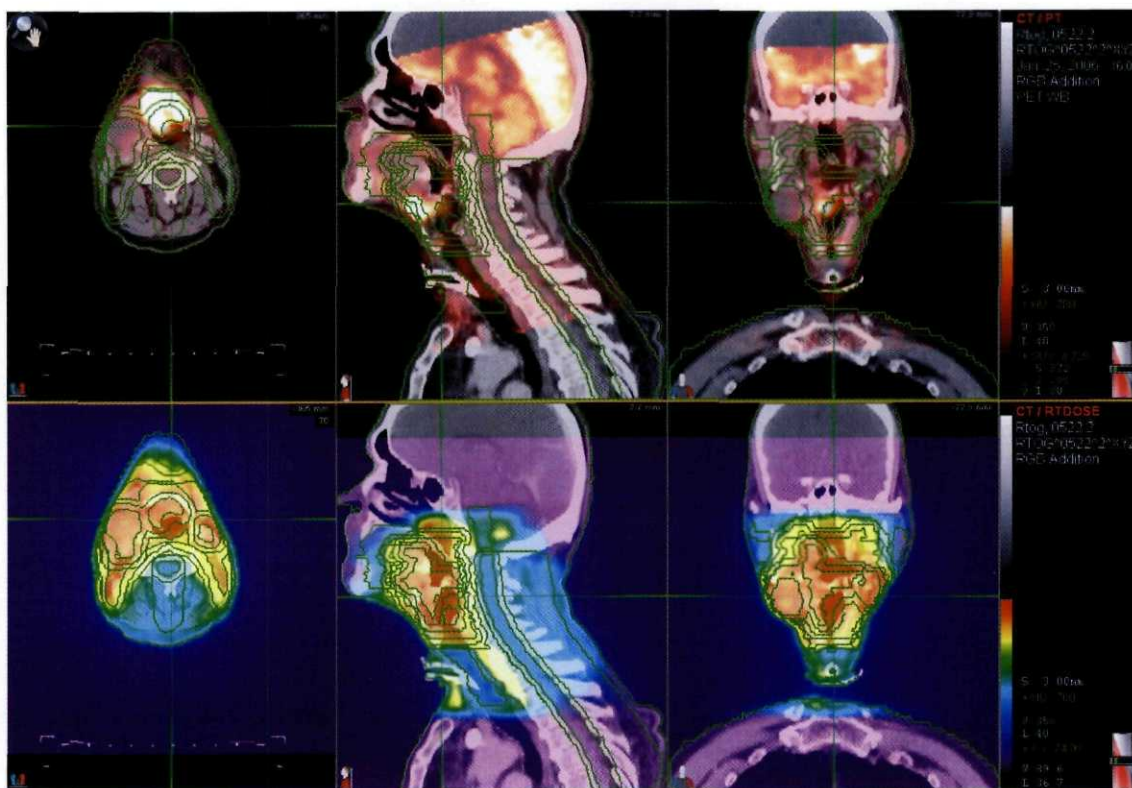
MIMvista display of RTOG 0522 data set (PET fused to planning CT with dose displayed)
